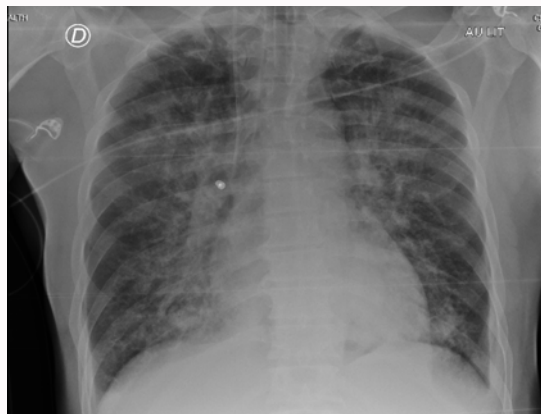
Chest X-ray on patient admission.
